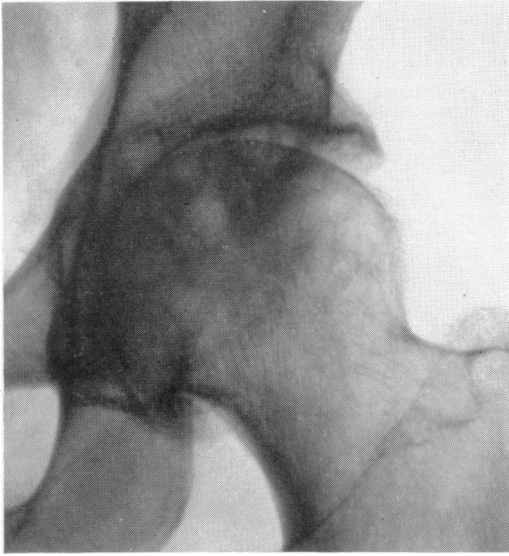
A radiograph showing incipient protrusio acetabuli. The medial joint space is lost and the inner wall of the acetabulum is thin and is tending to bulge inwards
